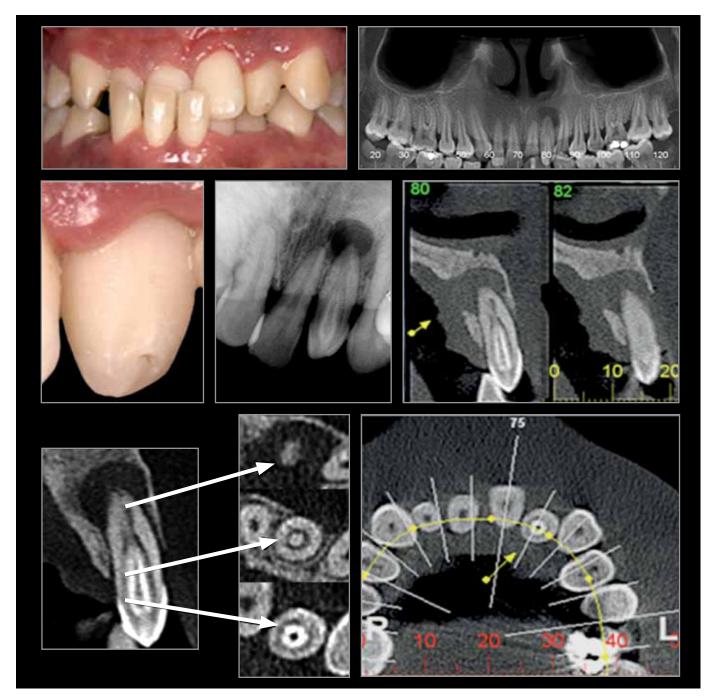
In sagittal and axial CBCT views it may be observed the presence of dens invaginatus type 2 of Oehlers. Periapical radiolucency with presence of the periapical bone cortical destruction was detected in palatal surface, and loss of buccal bone cortical until apical third can be also visible.
